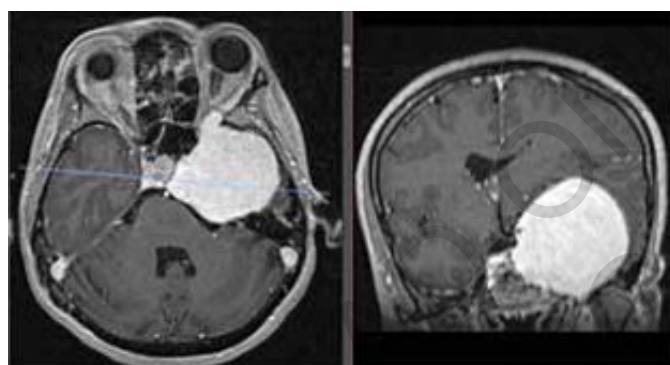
Pre-operative T1 post-contrast MRI.
